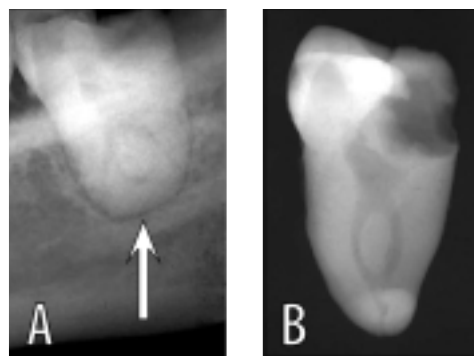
Bucco-lingual dilacerations need careful radiographic scrutiny for the “bull’s eye” sign shown in the pre-extraction radiographic detail (A). Radiographs of the extracted tooth are
